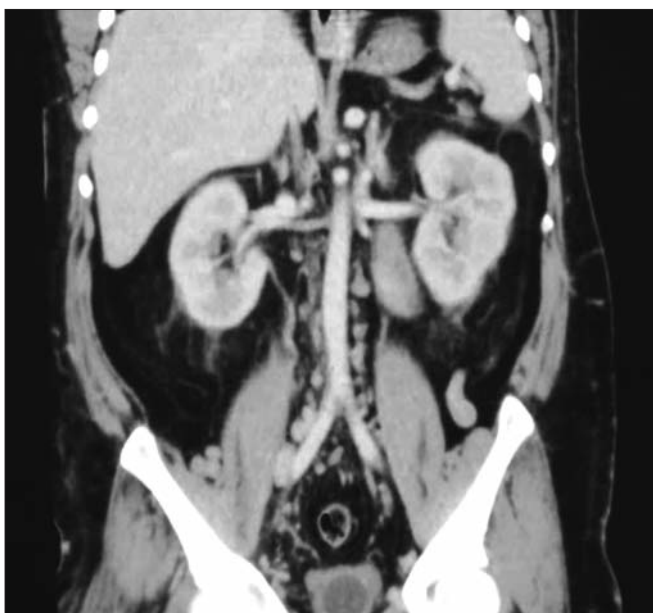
CT scan – coronal plane (personal archive)
